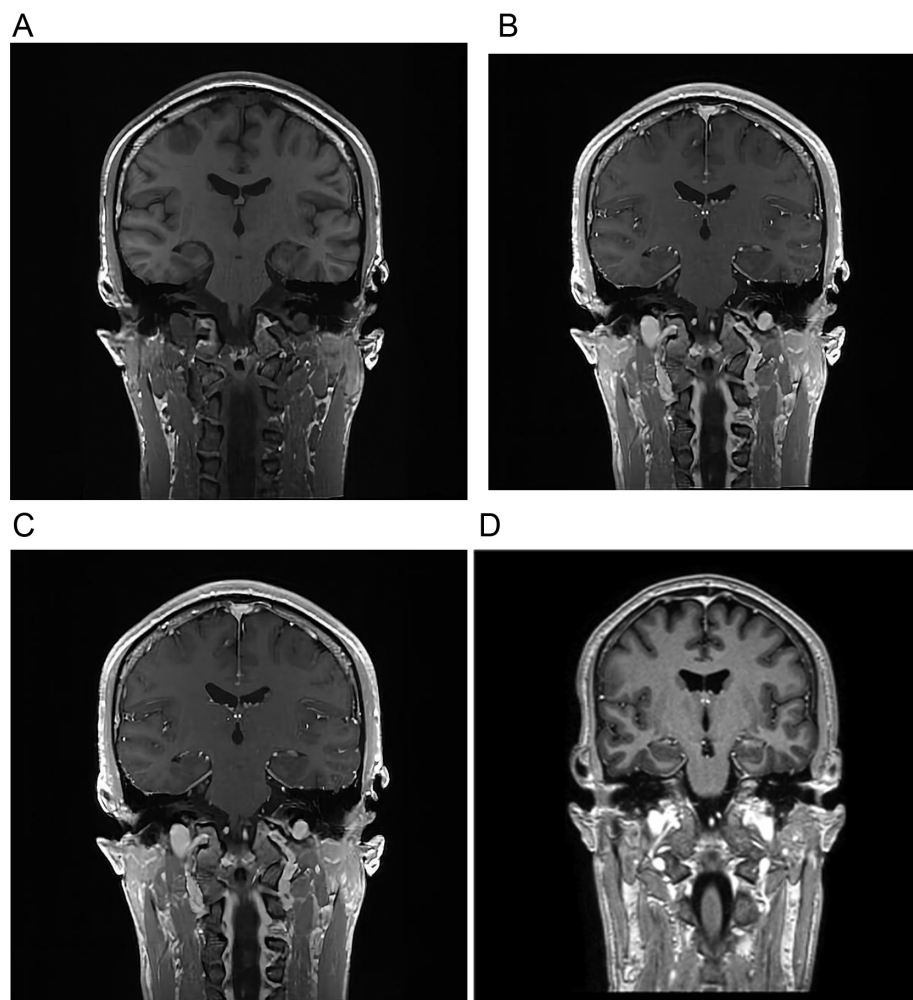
Coronal precontrast (A) and postcontrast (B) T1-weighted magnetic resonance (MR) images of the same patient (no. 11), rated as 0, no enhancement, bilateral. The patient did not develop hearing loss. Coronal precontrast (C) and postcontrast (D) T1-weighted MR images of the same patient (no. 15), rated as 0, no enhancement, bilateral. The patient developed left-sided mild-to-moderate hearing loss.
